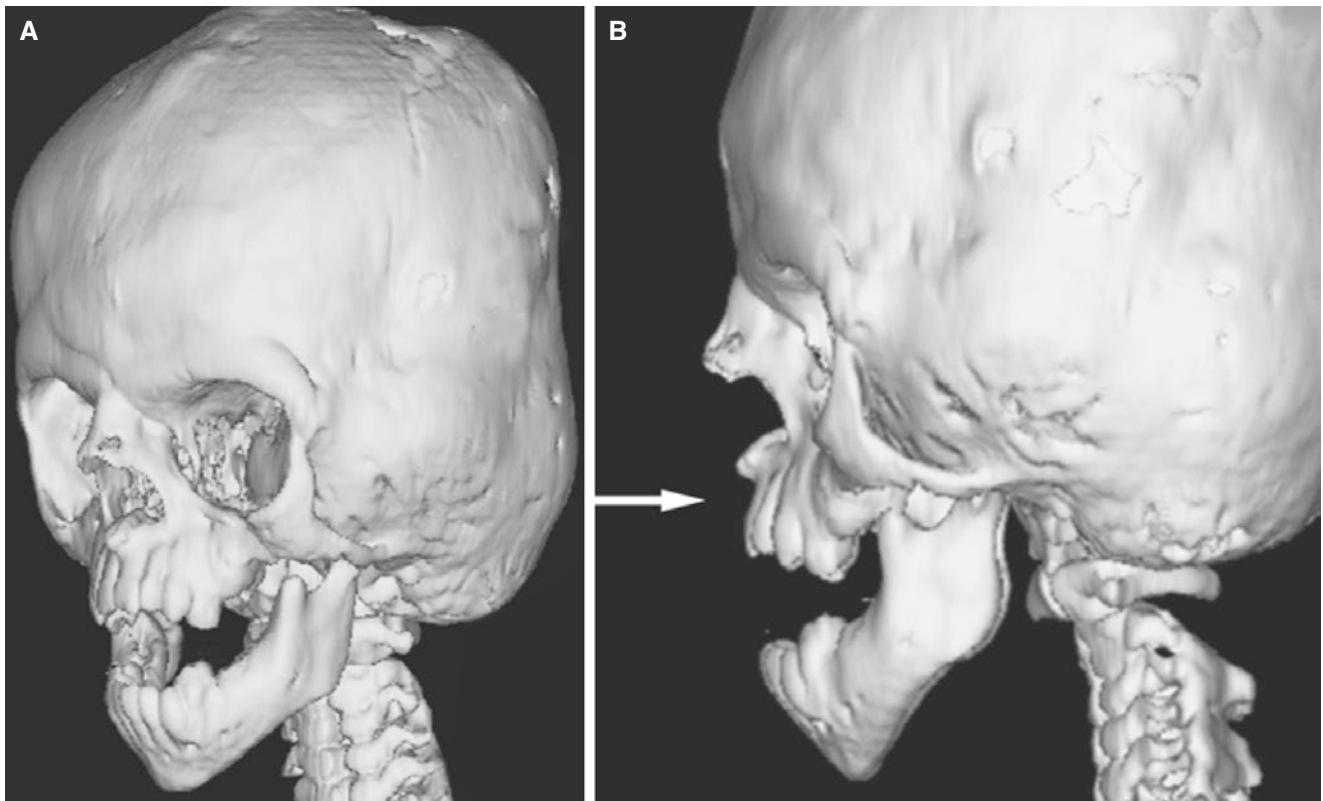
Crouzon syndrome; 2-year-old. (A) 3D CT image, oblique view, shows superior elongation of the skull and typically “opened mouth.” The maxilla and zygomas are hypoplastic. (B) 3D CT image, lateral view, shows maxillary hypoplasia (*arrow*)
